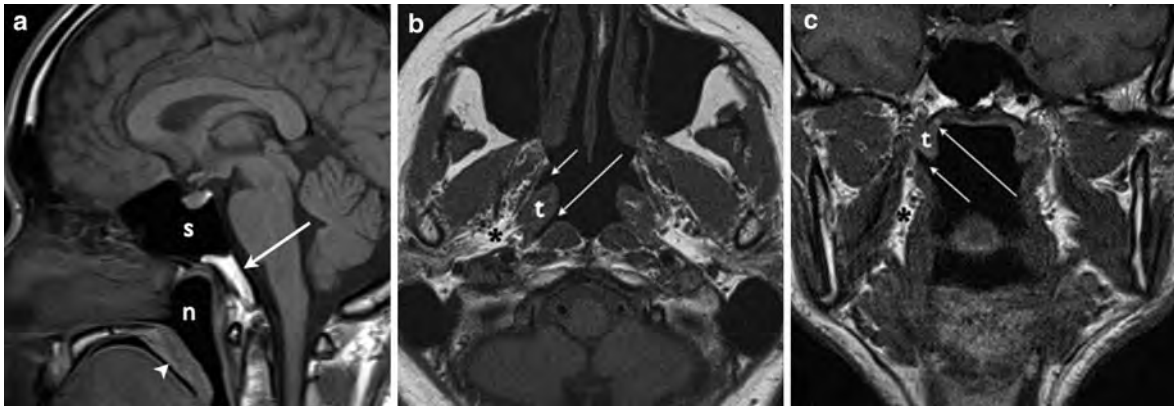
Imaging anatomy of the nasopharynx. a Sagittal T1-weighted MR image shows the nasopharynx (n), sphenoid sinus (s), clivus (arrow) and soft palate (arrowhead). b Axial T1-weighted MR image shows the right eustachian tube opening (short arrow), torus tubarius (t) and lateral pharyngeal recess (long arrow). The hyperintense fat in the parapharyngeal space
